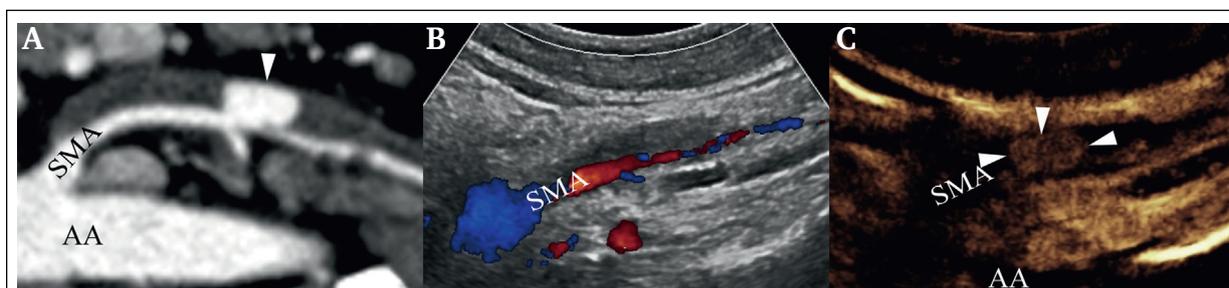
Imaging findings in a patient with a dissecting aneurysm. (A) Computed tomography angiography image shows a double barrelled dissection; the false lumen is dilated (arrowhead). (B) Colour duplex ultrasound image of the SMA shows the luminal stenosis. (C) Contrast enhanced ultrasound image shows contrast enhancement of the false lumen (arrowheads), which represents a dissecting aneurysm. AA = abdominal aorta; SMA = superior mesenteric artery.
